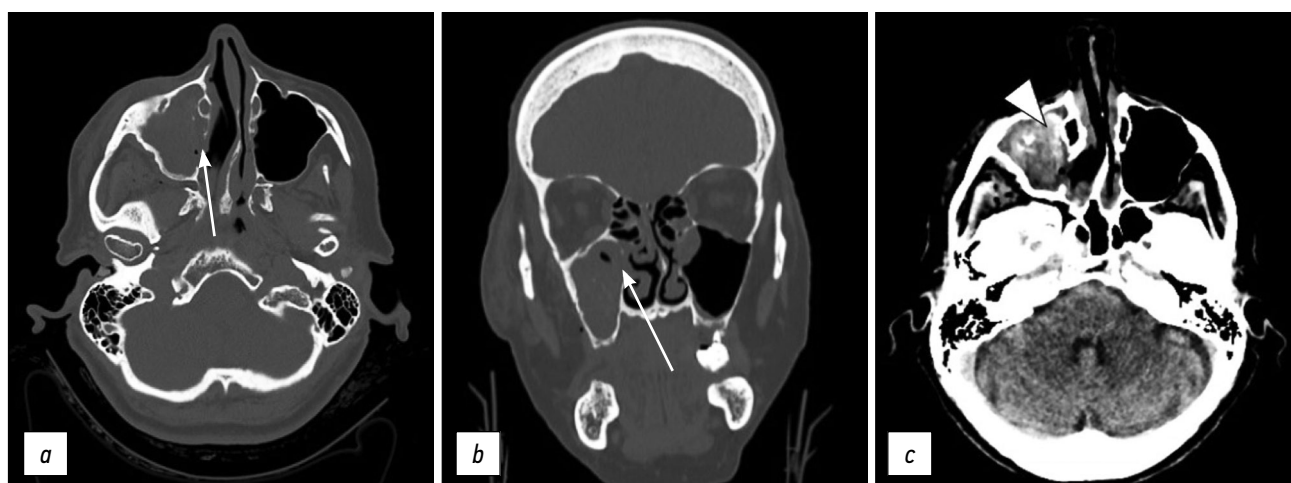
Axial (a) and coronal (b) CT scan with bone window documents the fracture of the medial wall of the right maxillary sinus (arrows). Soft window (c) shows hemosine in the right maxillary sinus (arrowhead).
